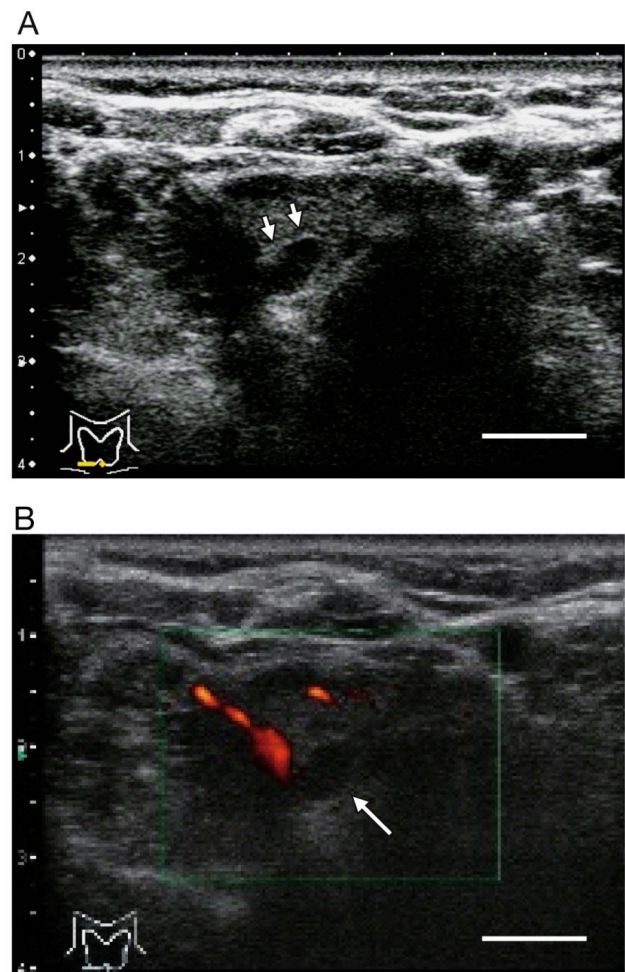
Ultrasonograms of intrathyroidal parathyroid adenoma (Patient 4). Scale bar, 10mm. A. B-mode ultrasonogram. Hyperechoic line is clearly detected (arrow), although the adenoma is 5mm in diameter. B. Power Doppler ultrasonogram. Arrow shows intrathyroidal parathyroid adenoma. Feeding vessels were not identified.
